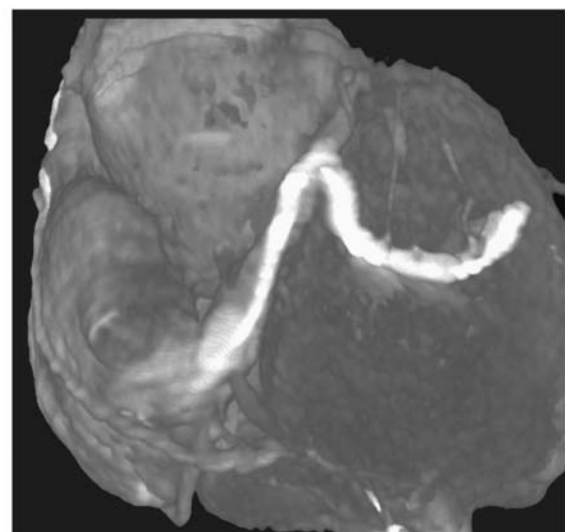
Fluoroscopy image demonstrating biventricular pacing leads and CT image demonstrating the position of the coronary sinus lead. RA = right atrial lead, RV = right ventricular lead, and LV = coronary venous lead.
